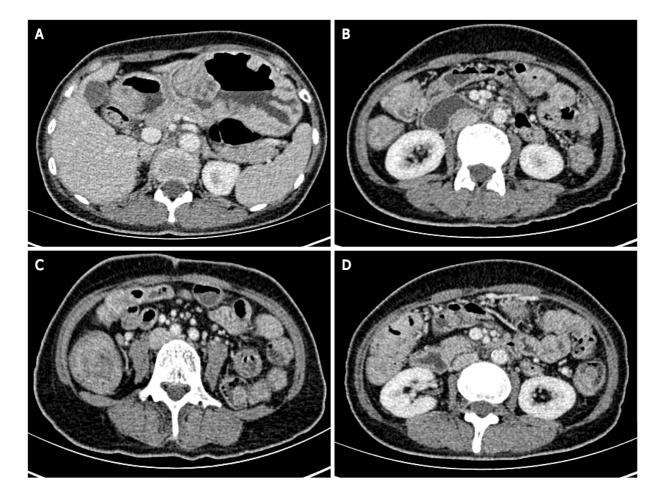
Abdominal enhanced computed tomography. Thickening of the gastrointestinal tract with multiple cauliflower-like and nodular protrusions. A: The stomach wall; B: Part of the small intestinal wall; C and D: Part of the colon wall.
